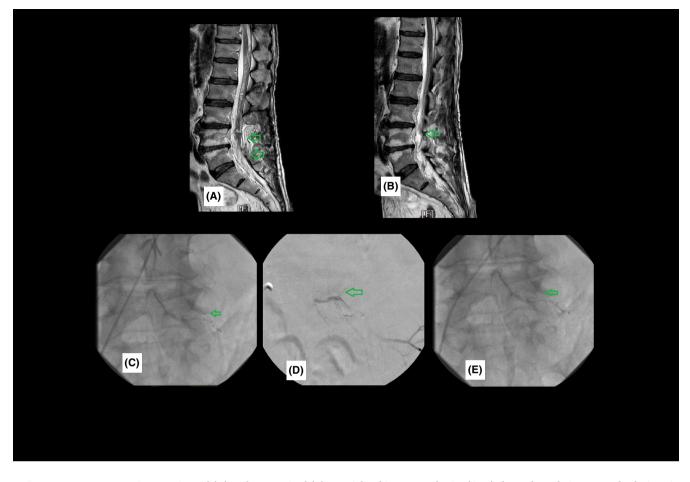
Postoperative MRI in mid (A) and parasagittal (B) T-weighted images and DSA (C–E) showed no obvious vascular lesions in follow-up studies. Green arrows: postoperative vascular treatment scar with minimal residues. Please note the complete feeder and draining occlusion.
